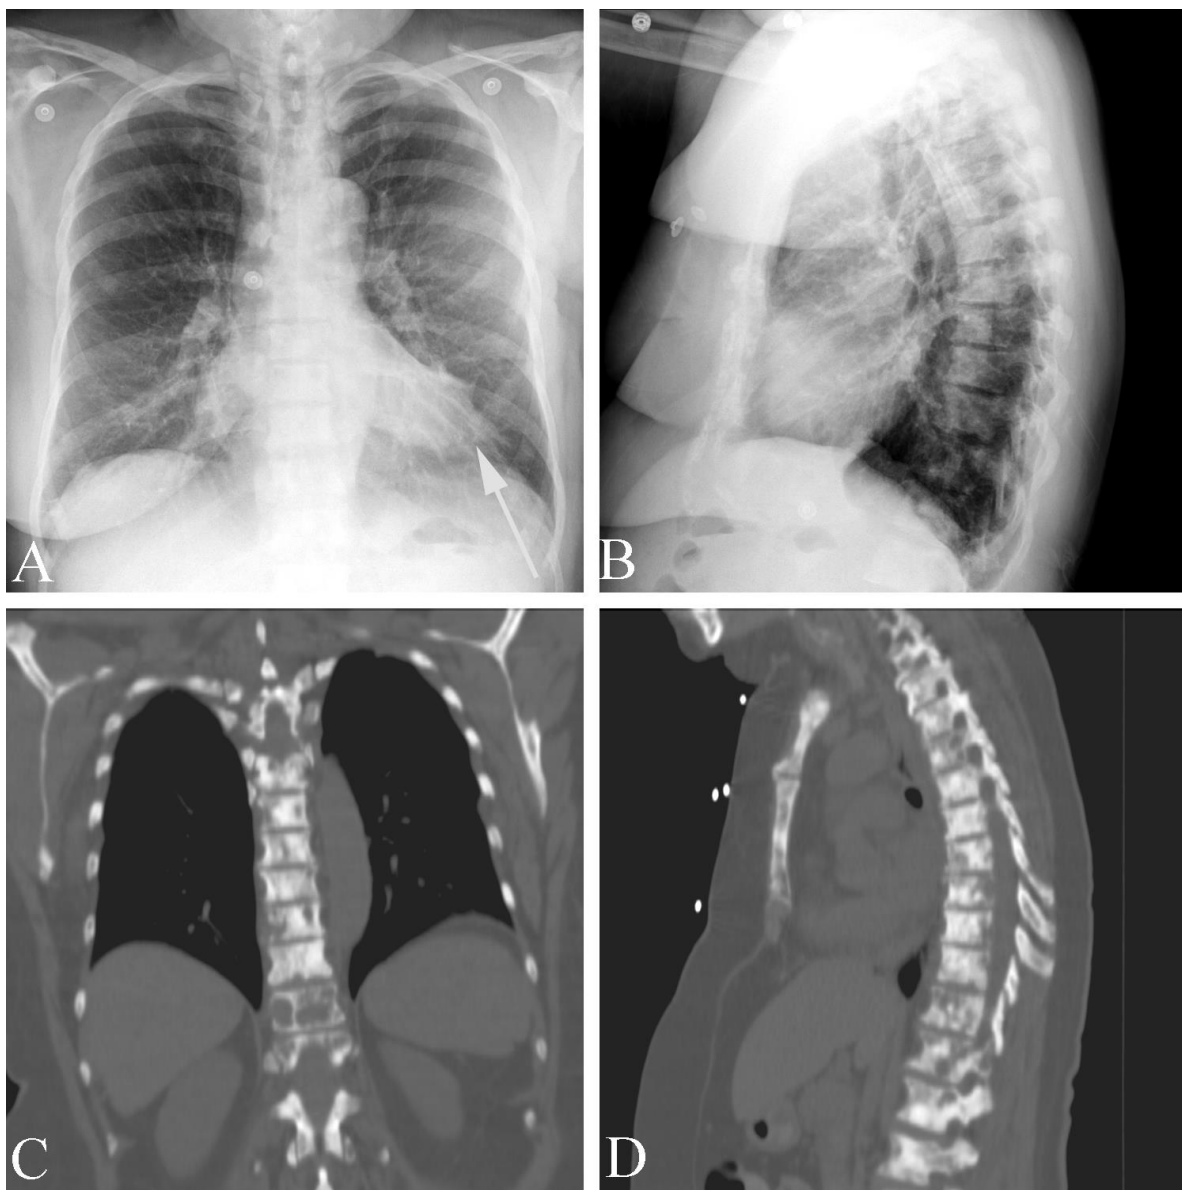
Metastatic breast cancer in a 70 year old woman with chest pain. A. PA CXR shows superior retraction of the left breast shadow (arrow). The patient had *not* had a mastectomy or any left breast procedure: the breast was retracted because of a tumor. B. Lateral CXR shows subtle patchy sclerotic change of the vertebral bodies. C. Coronal reformatted CT study demonstrates diffuse metastatic disease of the spine. D. Sagittal reformatted CT demonstrates diffuse metastatic disease of the thoracic spine and sternum.
